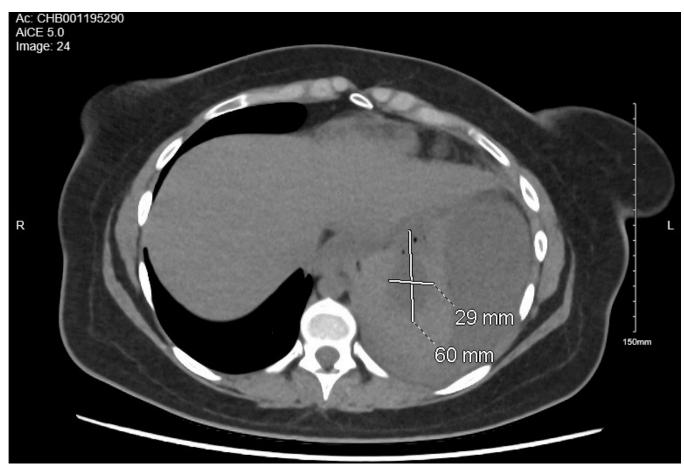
Axial CT abdomen view of intraparenchymal abscess
